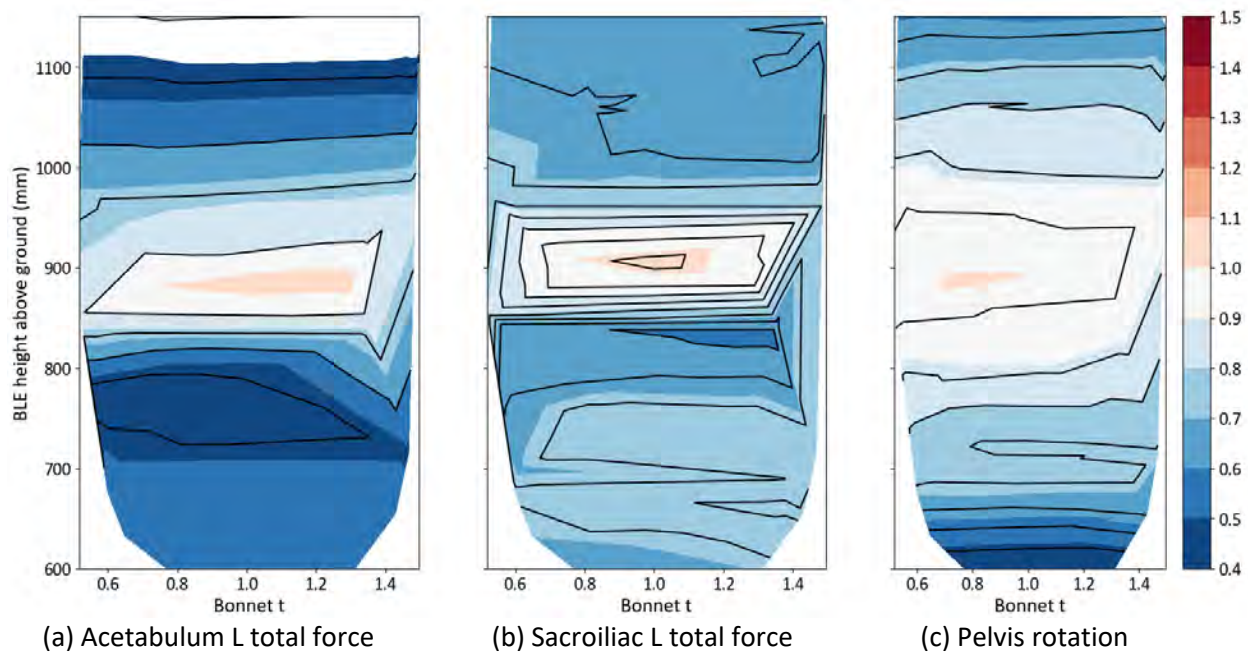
Normalised maximum HBM pelvis injury values for the struck side (left pelvis of the HBM) at test position Y+600 for the SUV by varying the exterior sheet thickness of the bonnet and the shooting height of the HBM (converted to BLE height above ground).
